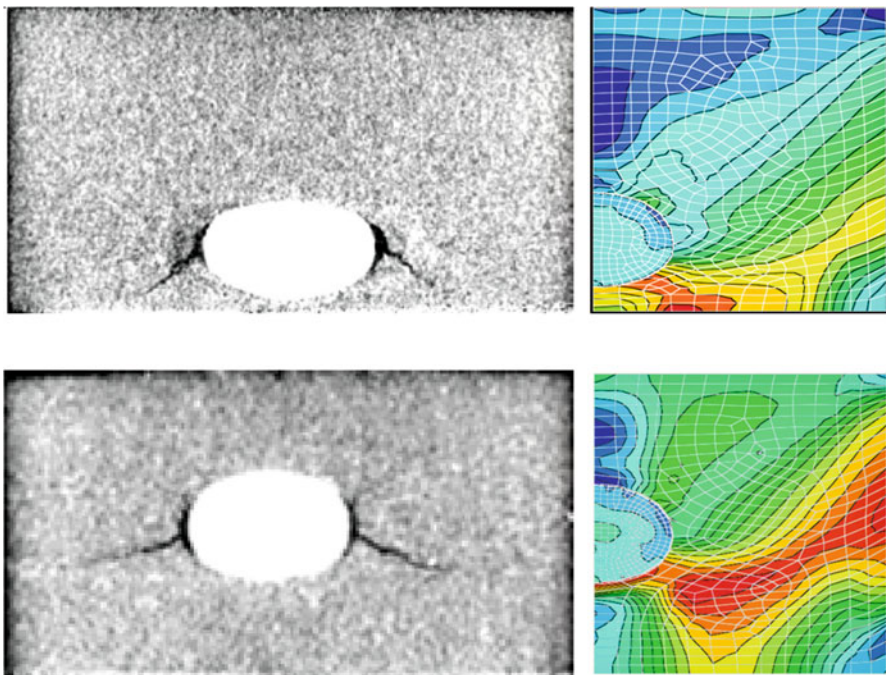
Tablet fracture induced by entrapped air analysed using FEM (*right column*) and X-ray computed tomographic imaging (*right column*): the *top row* shows the results when the ‘air pocket’ is close to the tablet surface; the *bottom row* shows the results when the ‘air pocket’ is located in the centre of the tablets
